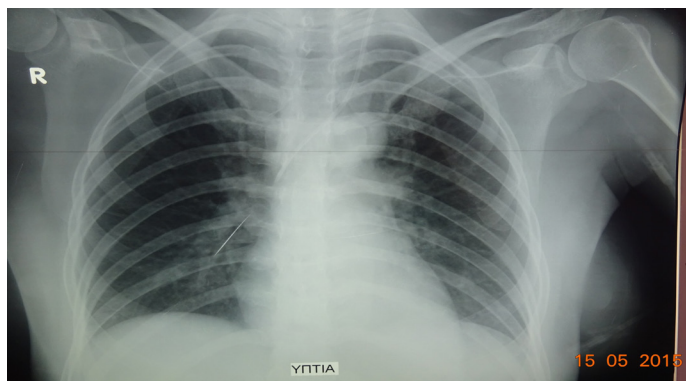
Thorax-X-Ray (1st Day in the ICU)
